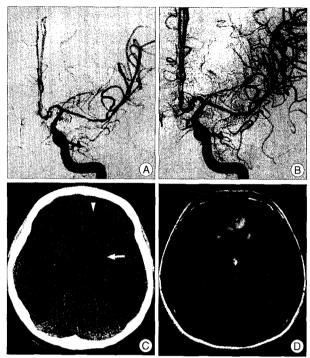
A 24-year-old woman presented with subarachnoid hemorrhage and a ruptured aneurysm. On 10 days after coil embolization of aneurysm, left internal carotid angiography (A) reveals moderate arterial vasospasm, which is improved after intra-arterial administration of nimodipine (IAN) (B). A brain computed tomography (C) at 2 days after IAN shows low-attenuating lesions in the left globus pallidus and internal capsule (arrow), as well as in the medial aspect of the anterior frontal lobe (arrowhead). On 3-month follow-up fluid attenuation inversion recovery (FLAIR) magnetic resonance image (D), the basal ganglia lesion disappears. Conversely, the lesion in the medial aspect of the anterior frontal lobe is persistent.
